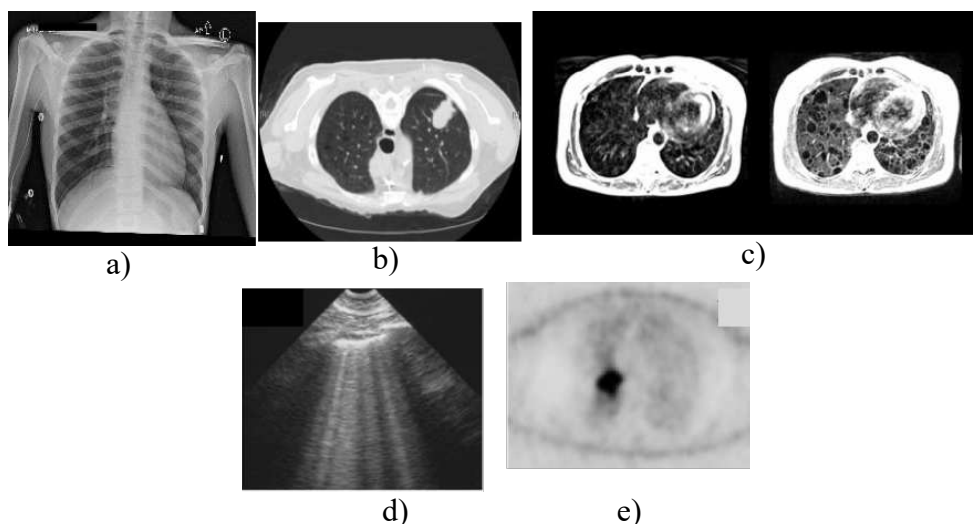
Lung Imaging using, a) X-Ray [5], b) CT [6], c) MRI [7], d) Ultrasonography [8], e) PET [9]
